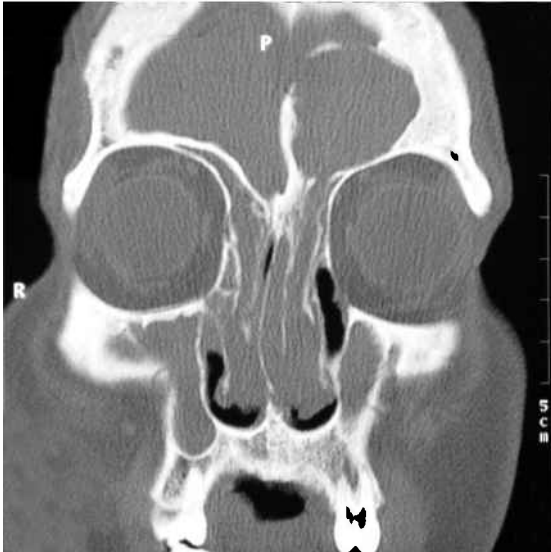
Coronal CT shows the left frontal mucocoele.
